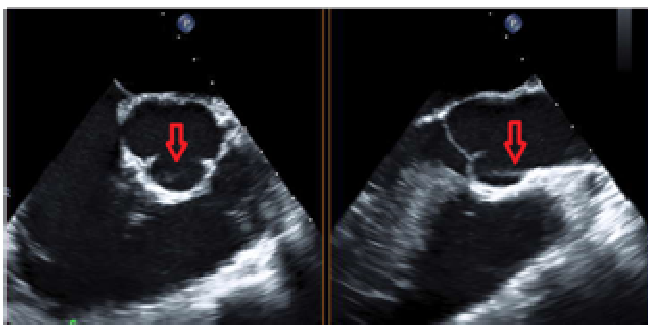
Two views of the ascending aorta on the trans-esophageal echocardiogram show the intimal flap just above the aortic valve (red arrows).
